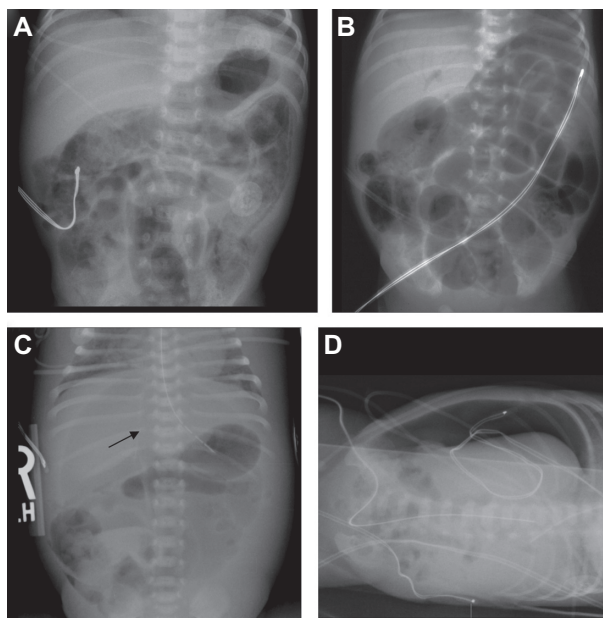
Abdominal radiographs with characteristic findings of necrotizing enterocolitis. (A) Diffuse pneumatosis intestinalis with a linear distribution in the left upper and middle quadrants. (B) Characteristic arborization pattern of portal venous gas. (C) Free peritoneal gas with the falciform ligament visible (arrow). (D) Free peritoneal gas seen in a left lateral decubitus view.
